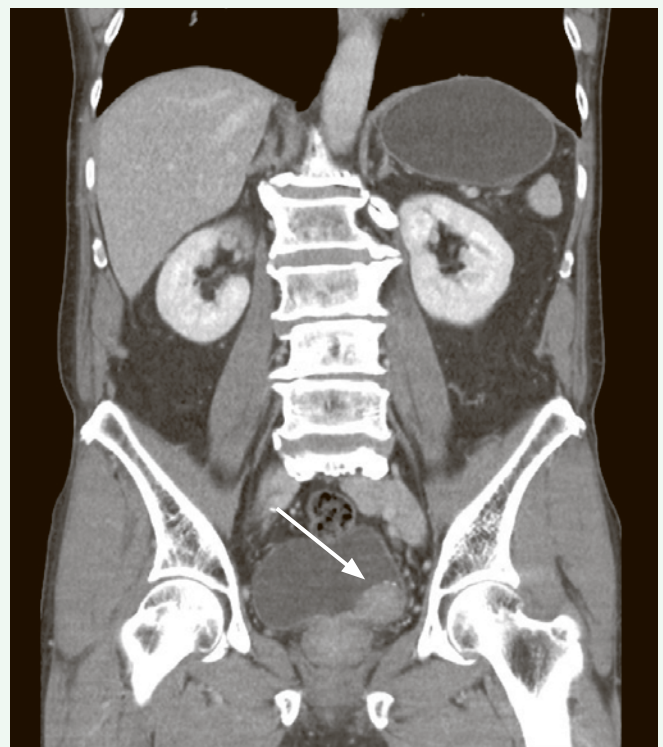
Bladder mass (arrow) shown on contrast CT urogram
